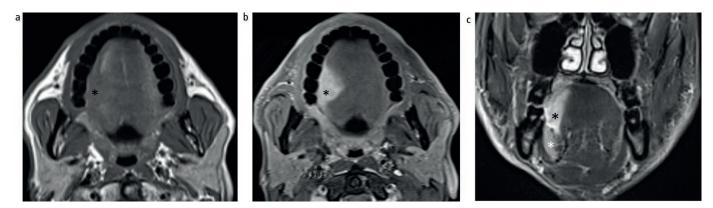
MRI of oral tongue SCC. (a) axial T1-weighted image shows tumour as isointense lesion (black *) which becomes more conspicuous (black *) on the axial fat-supressed post-gadolinium enhanced T1-weighted image (b). (c) Coronal STIR image shows high signal tumour (black *) at the right lateral aspect of the tongue abutting inferiorly at the right sublingual gland (white *) in the floor of the mouth
